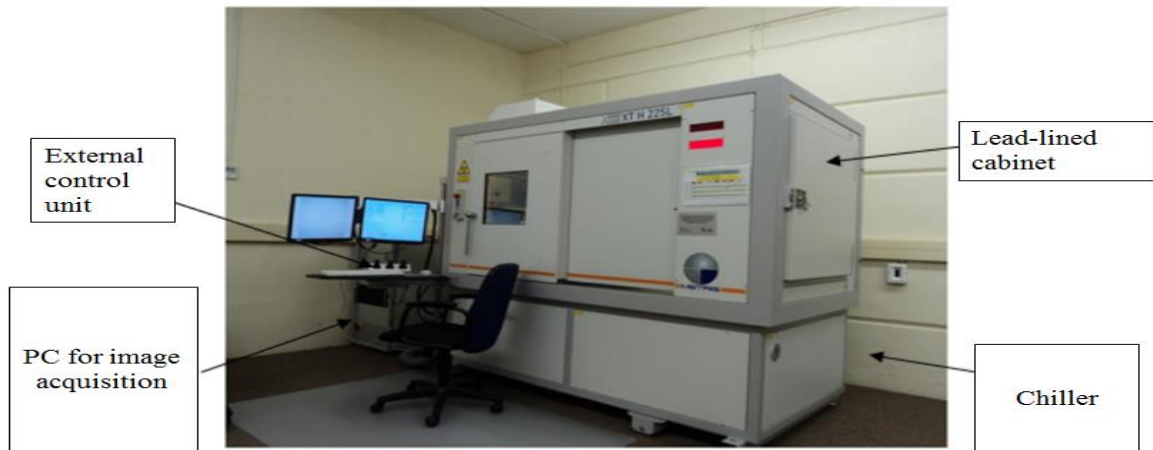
Micro-focus X-ray machine (Hoffman, 2012).
